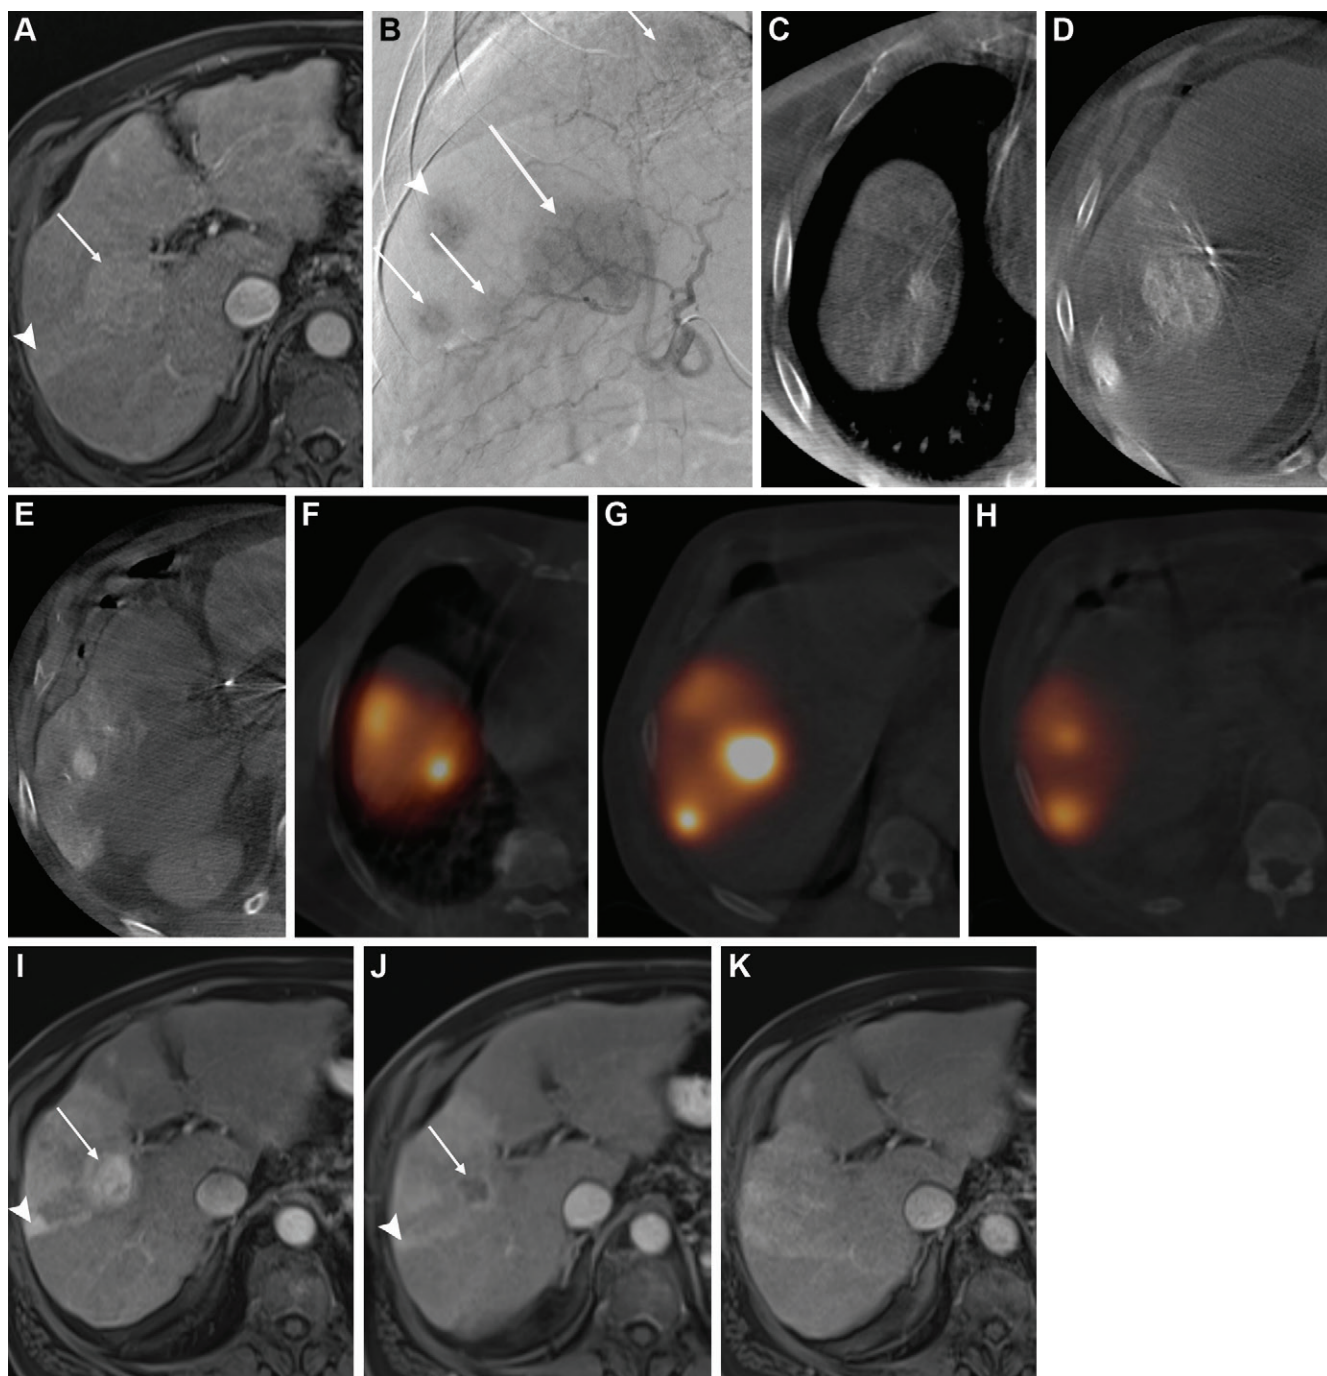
Images in a 64-year-old man with multifocal hepatocellular carcinoma (HCC) in the right lobe. (A) Arterial phase axial T1-weighted gadolinium-enhanced volumetric interpolated breath-hold examination (VIBE) image shows two HCCs (arrow and arrowhead) on the border of segments V and VIII. Three other HCCs in segments VIII and V are not shown. (B) Selective arteriographic image of the right hepatic artery shows five HCCs, two corresponding to those in (A) (large arrow and arrowhead) and three additional (small arrows). (C–E) Axial intra-arterial cone-beam CT images confirm the HCCs within the arterial territory of the anterior right hepatic artery. (F–H) Axial SPECT images after administration of 150-MBq technetium 99m-labeled macroaggregated albumin in the anterior right hepatic artery confirm tracer uptake by the HCCs. (I, J) Arterial phase axial T1-weighted gadolinium-enhanced VIBE images 3 months after selective yttrium 90 radioembolization at the level of (A) still show hypervascularity in the segment V and VIII HCCs (arrow and arrowhead), which disappeared 6 months later. (K) Arterial axial T1-weighted VIBE image at 15 months: no HCCs could be identified in the radiation-induced shrunken part of the right liver lobe. Ultimately, the participant was downstaged and underwent transplant 17.4 months after randomization.
